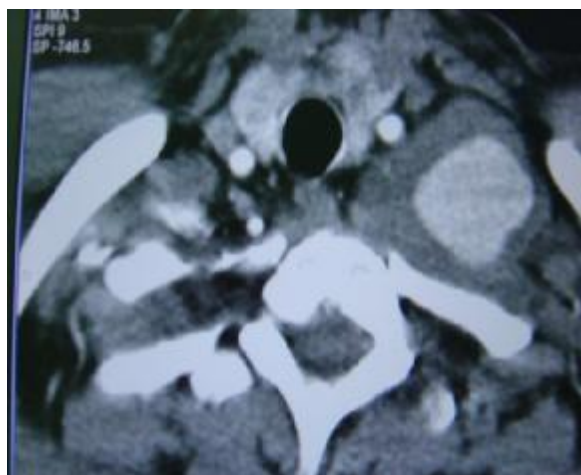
Two-dimensional CT angiography in Behçet's disease presenting with subclavian artery aneurysm.
